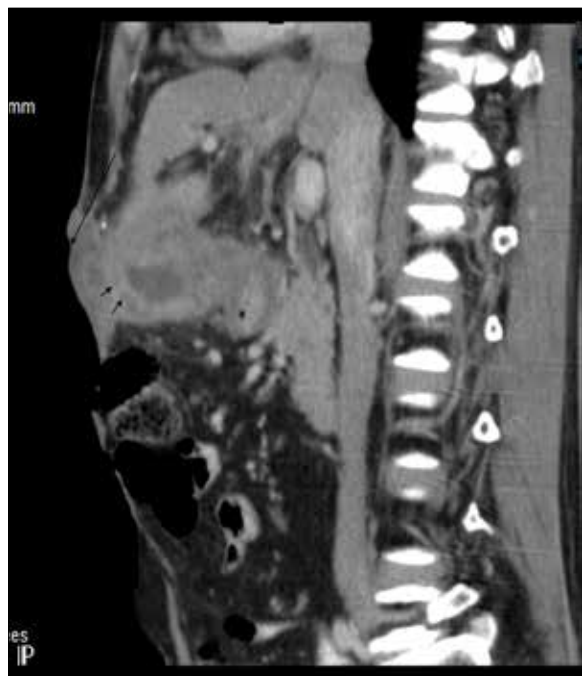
Sagittal reformatted contrast-enhanced CT showing GB fundus adherent to the anterior abdominal wall with ulceration of the overlying skin (long arrow). There is concentric thickening of the GB wall showing inhomogeneous enhancement (small arrows).
